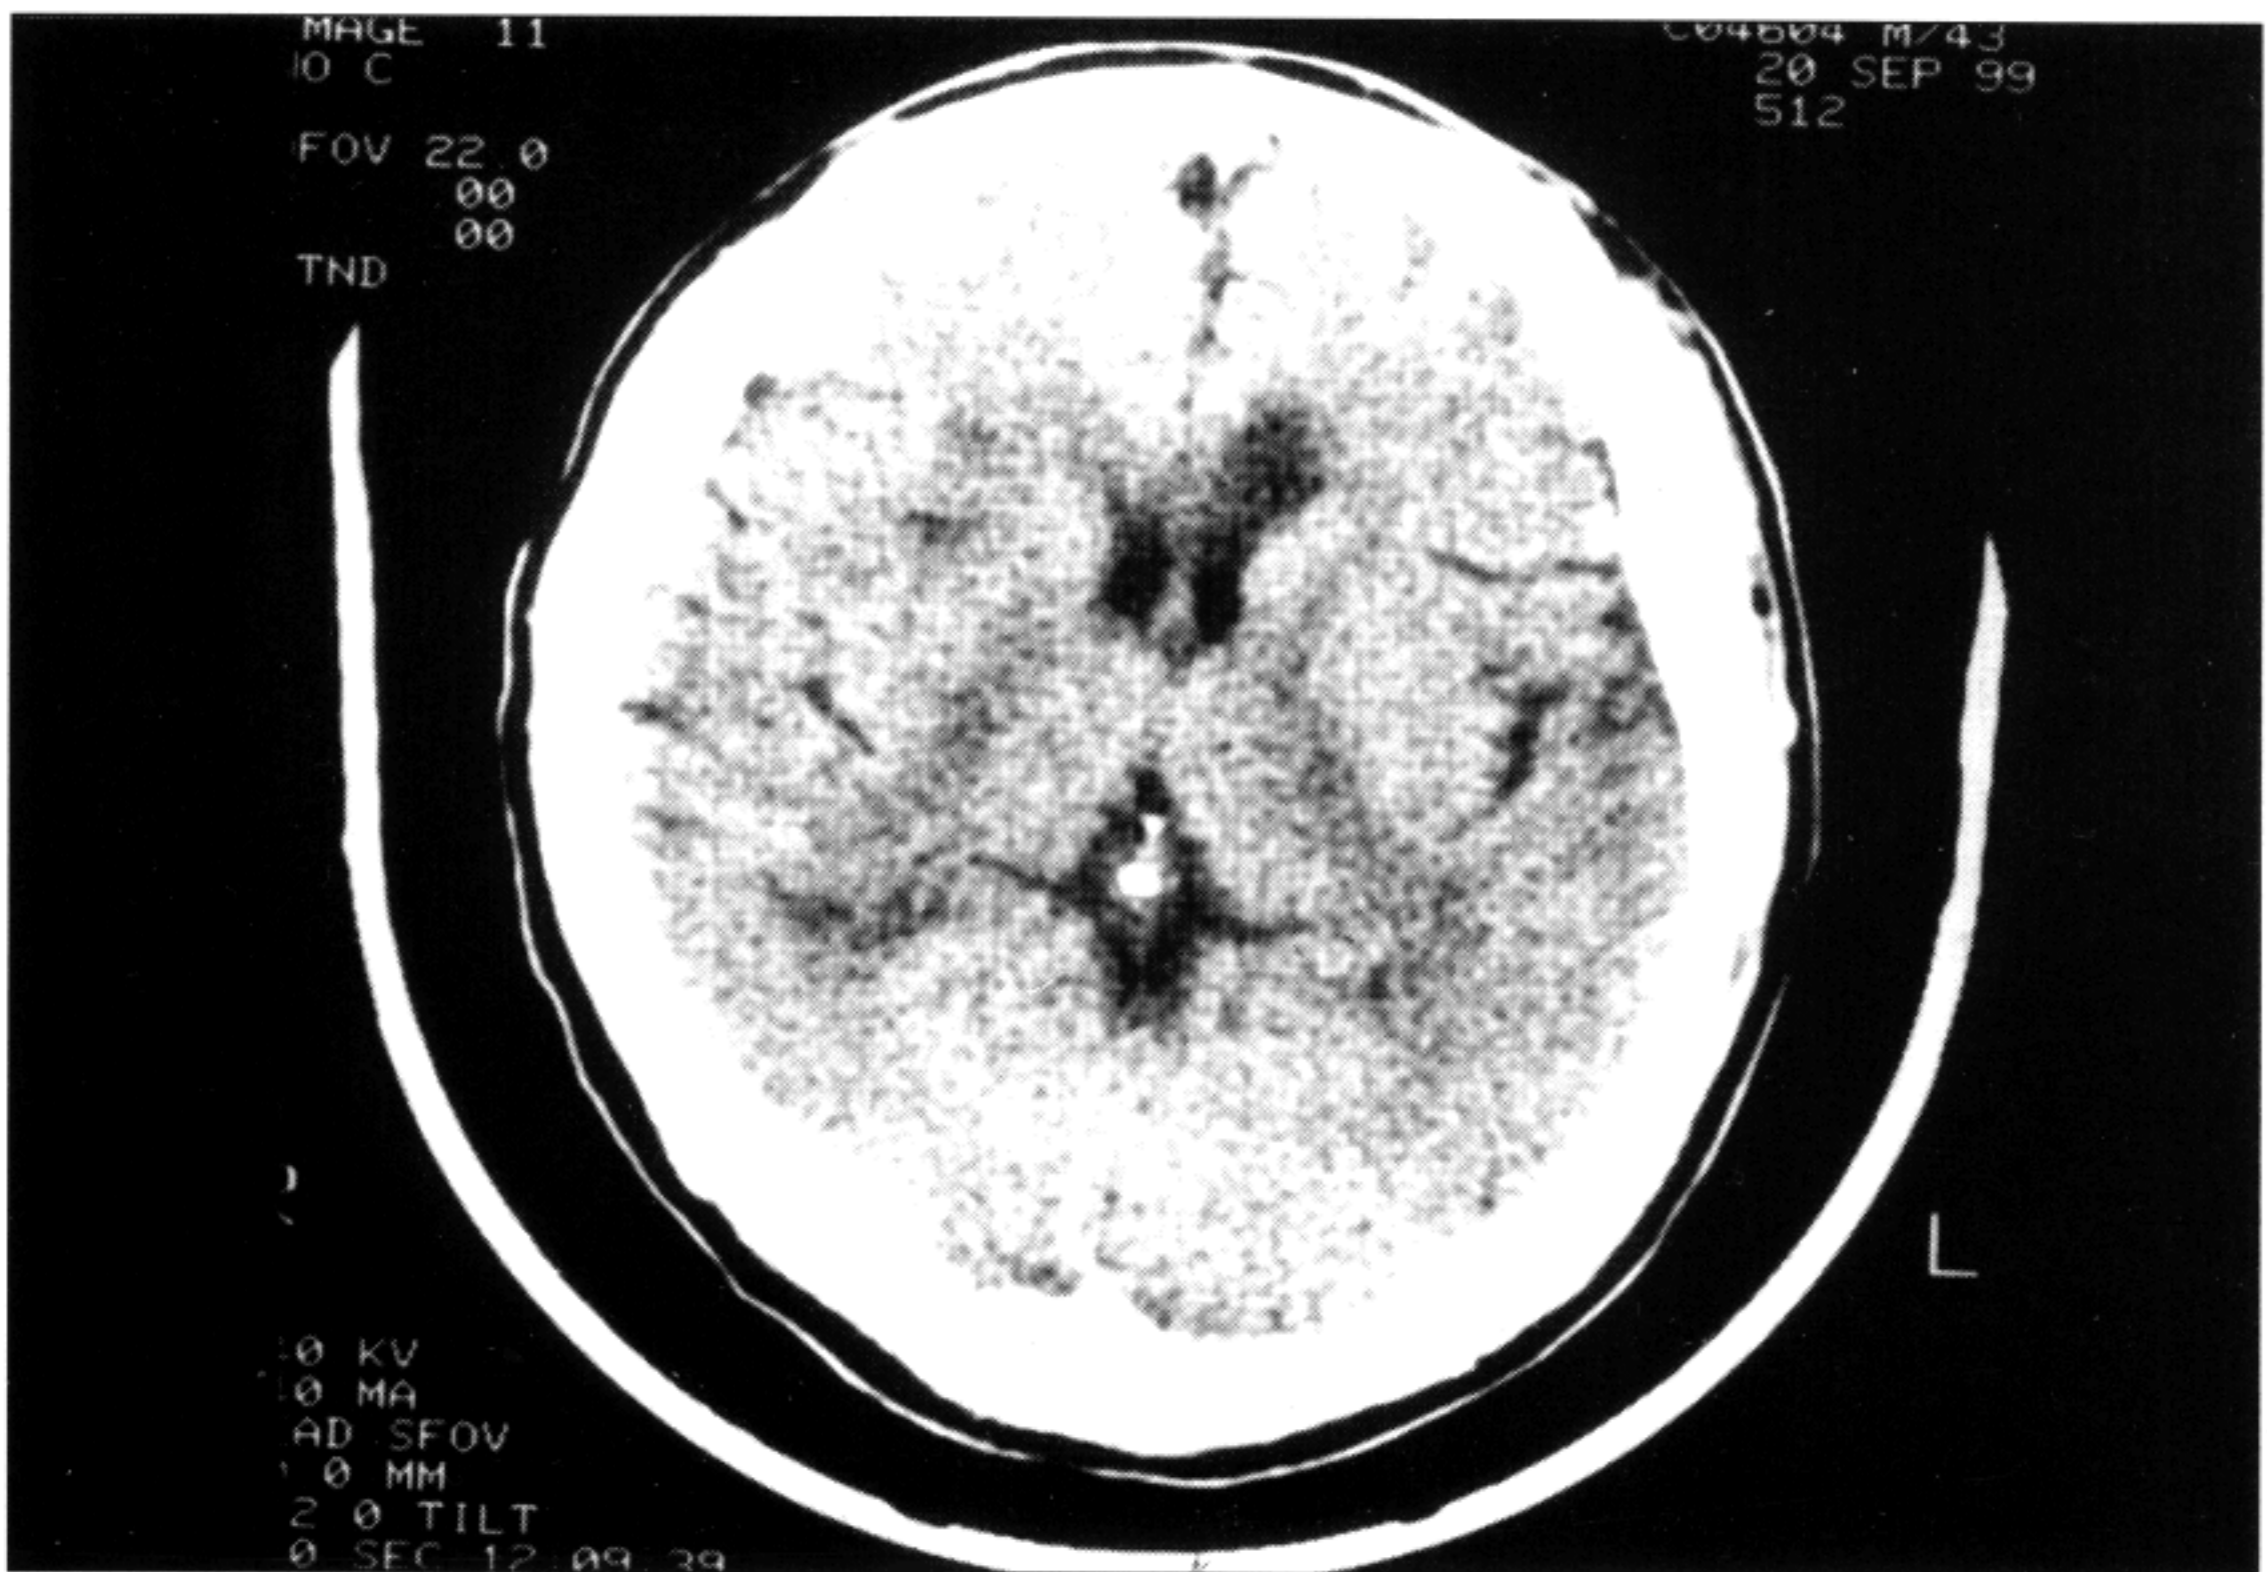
Pre-treatment axial non enhanced CT brain showing well defined hypodense area in the left corpus callosum.
